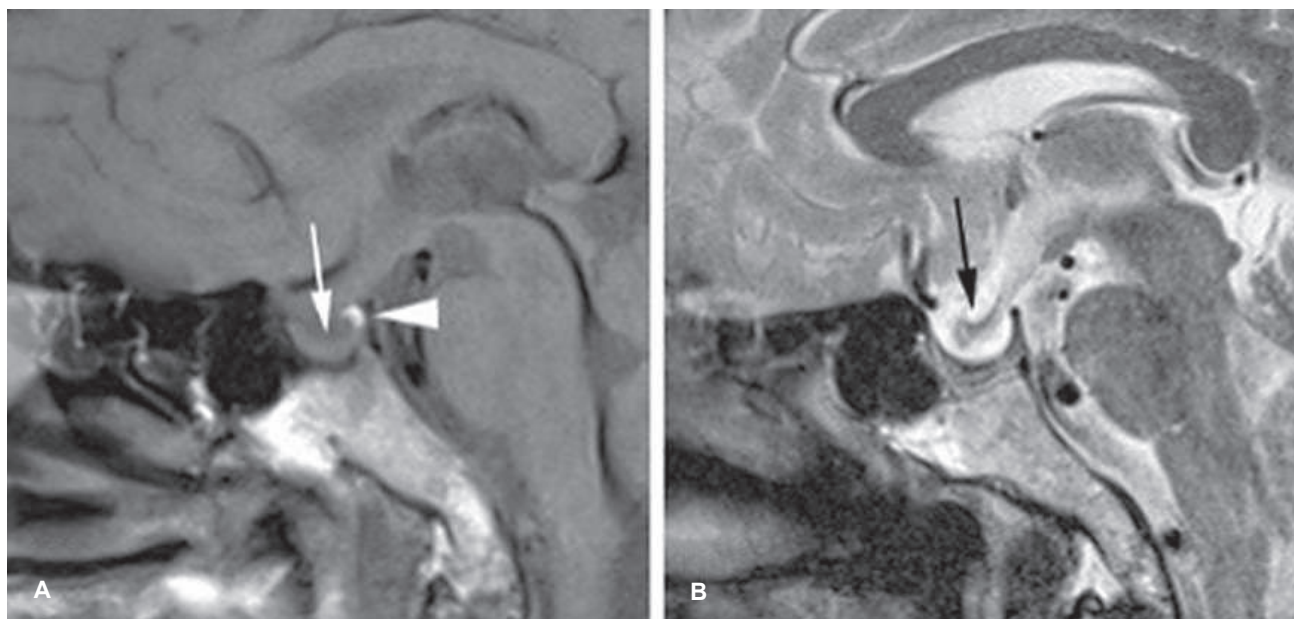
Follow up MRI in the midsagittal plane, T1-weighted (A) and T2-weighted images (B). The T1 hyperintense posterior pituitary (white arrowhead in A), with much of the anterior pituitary, flattened against the seller floor (white arrow in A). The optic chiasm is prolapsed inferiorly into the sella (black arrow in B).
